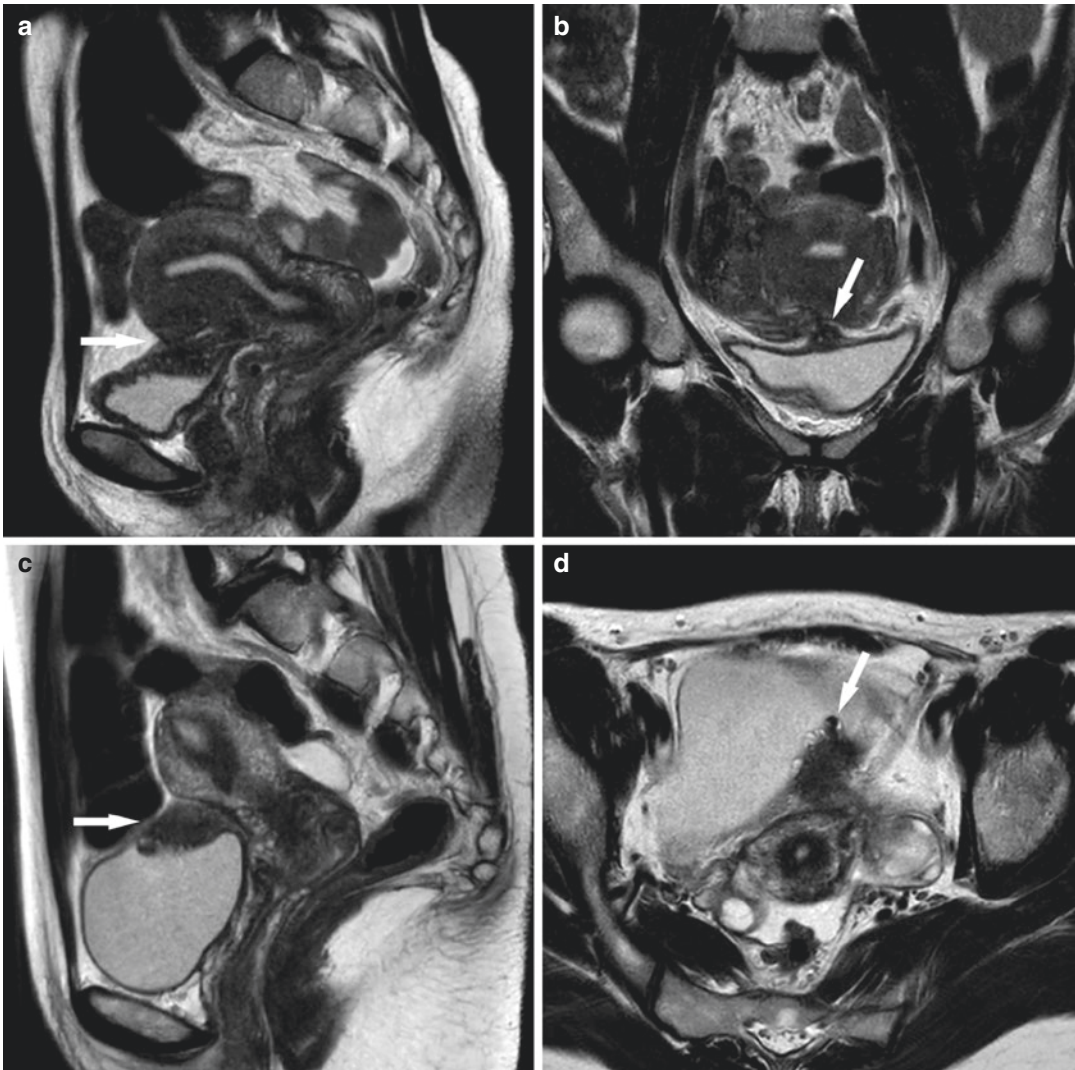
Anterior compartment. (a, b) Endometriosis of the vesicouterine pouch in a 34-year-old woman with pelvic pain. Sagittal T2-weighted (a) and coronal T2-weighted (b) MR images show irregular hypointense nodular lesion that adheres to the anterior uterine surface and to the upper bladder wall surface. The lesion obliterates the vesicouterine recess. Anteversion of the uterus is associated. (c, d)
